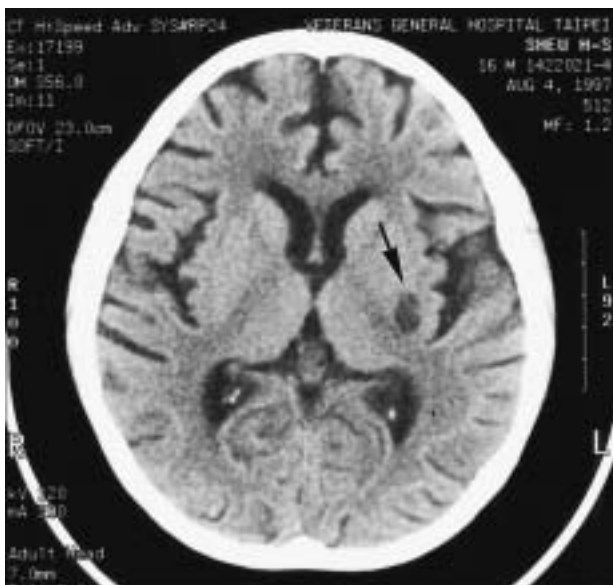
Computed tomography scan of the brain showing a low attenuation (arrow) over the posterior limb of the internal capsule of the left cerebrum.
